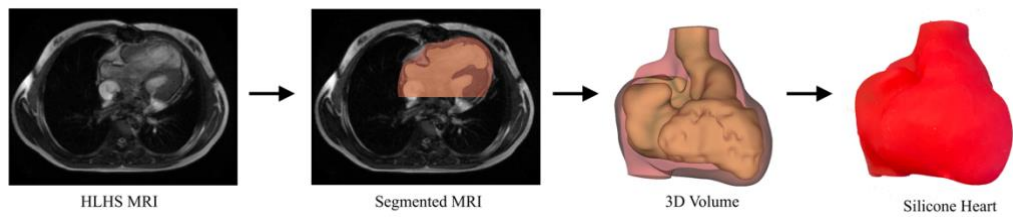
Silicone Heart Fabrication – A silicone synthetic heart was made from a HLHS MRI. The internal blood volume (orange) and myocardium (red) were segmented from the MRI, the 3D volumes were generated, and then molds were 3D-printed. Hearts were then casted with silicone for surgical training.
